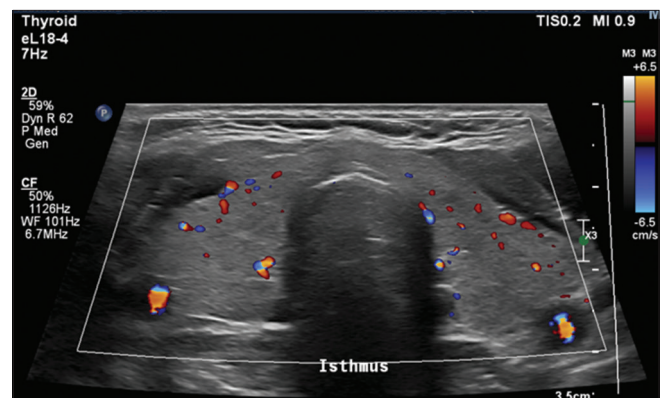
Thyroid ultrasound of Case 4 showing increased vascularity on color Doppler
